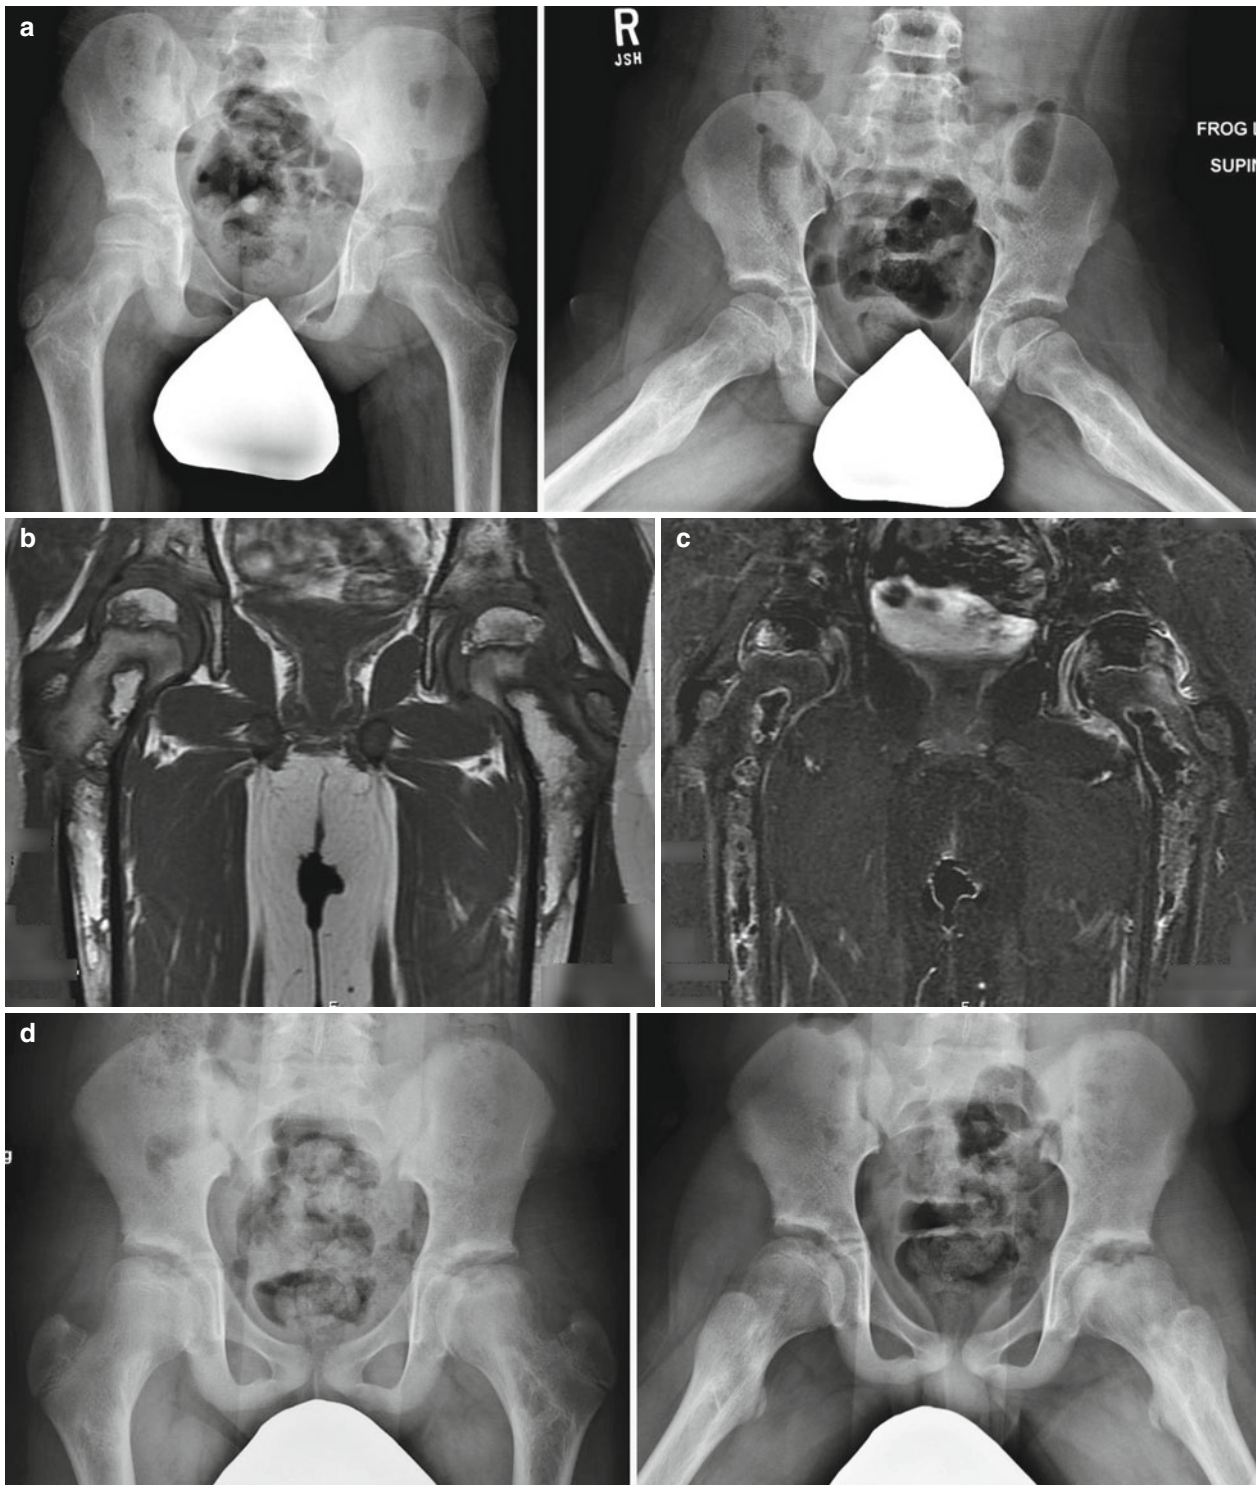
Radiographs and MRIs of a 10-year-old male with ALL being treated with chemotherapy that includes corticosteroids. The patient had bilateral hip and ankle pain. This patient was treated with decreased weight bearing using crutches and wheelchair for long-distance ambulation. For his ankle pain, bilateral ankle foot orthoses (AFO) were prescribed. (a) AP pelvis and frog-leg lateral radiographs showing serpentine areas of increased radiodensity in bilateral femoral metaphyses and an area of decreased radiodensity on the proximal diaphysis of left femur. (b) Non-contrast T1-weighted MRI showing fat signal changes in the femoral epiphyses, metaphyses, and diaphyses. (c) Contrast-enhanced subtraction MRI showing the areas of hypoperfusion (*black*) and hyperperfusion
